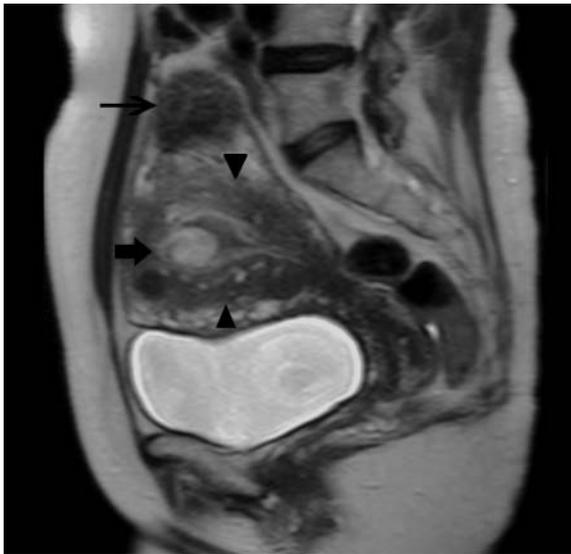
Leiomyoma, diffuse adenomyosis and endometrial polyp on MRI. T2-weighted sagittal image of a patient depicts diffuse adenomyosis (*arrowheads*) with symmetrical broadening of the junctional zone. An endometrial polyp exhibiting similar high signal intensity as the endometrium can be clearly identified within the uterine cavity (*short arrow*). A fibroid is present in the fundus (*long arrow*)
